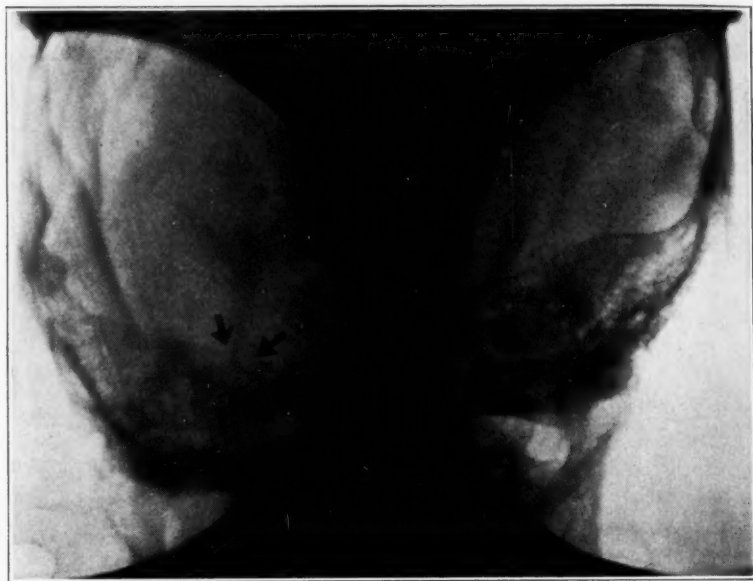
Roentgenograms showing osteomyelitis of the petrosa on the left side, causing dehiscence in the superior ridge of the petrous pyramid.
